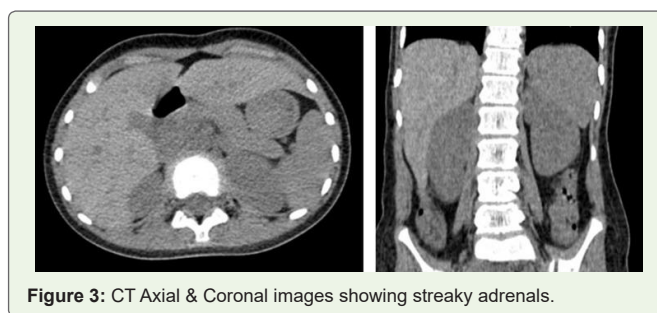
CT Axial & Coronal images showing streaky adrenals.
